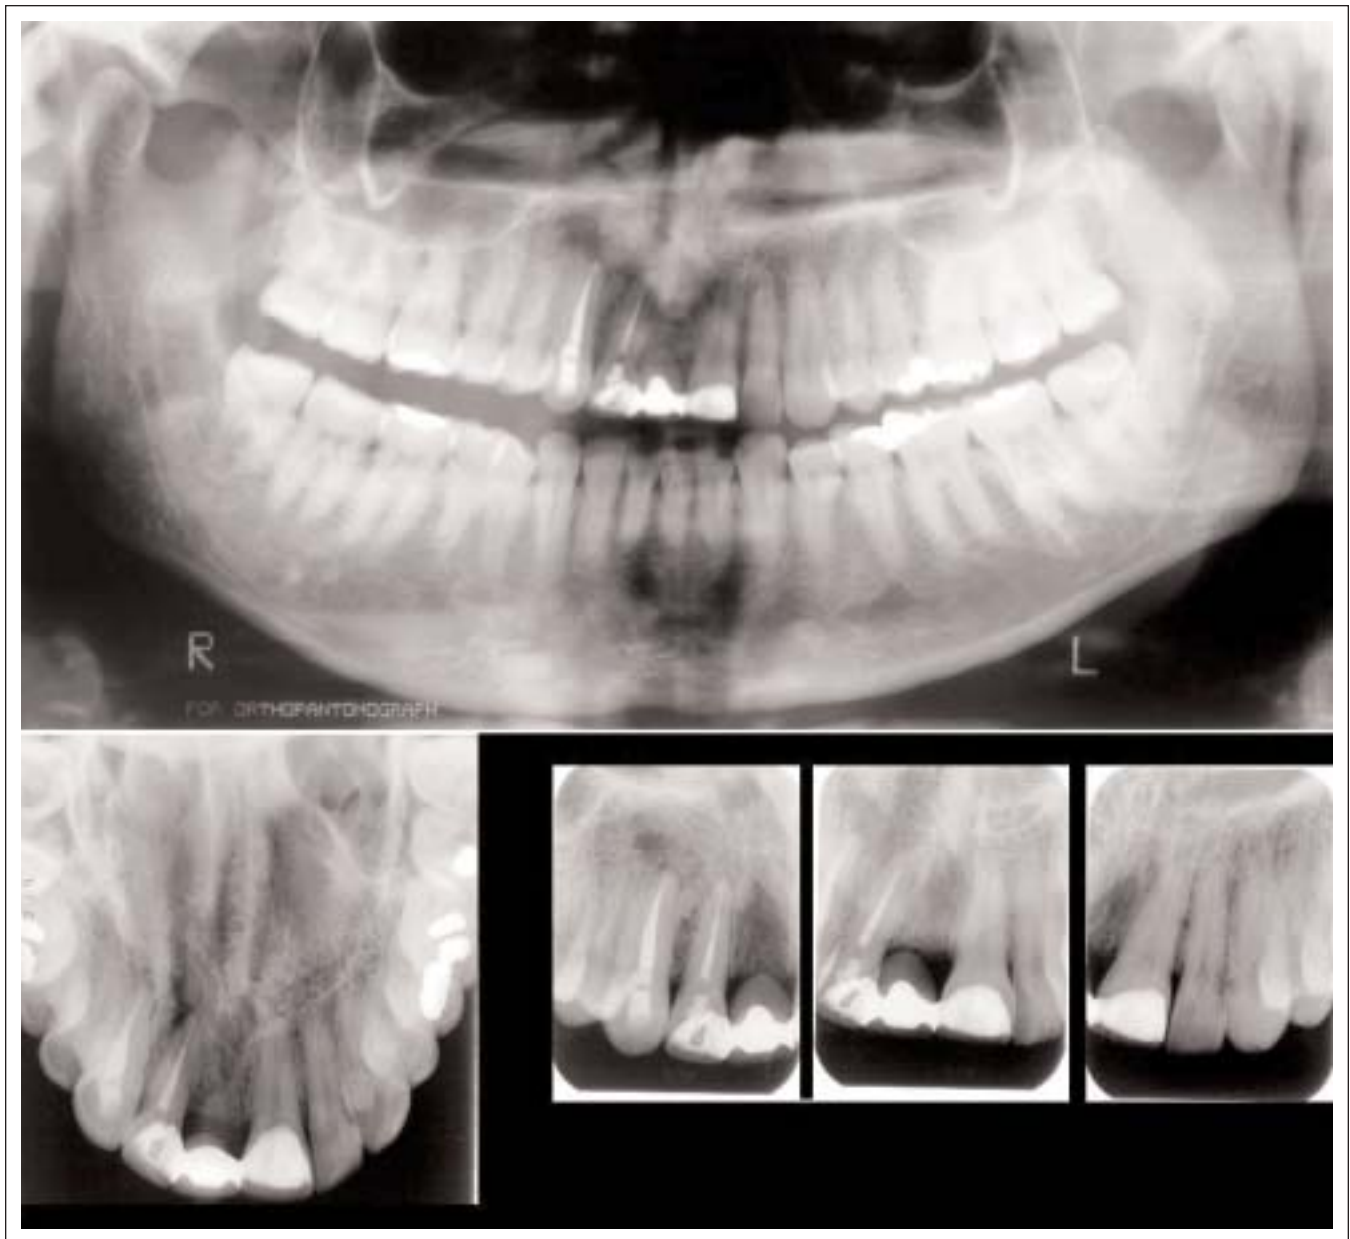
Postoperative Follow-up: Panoramic radiograph
